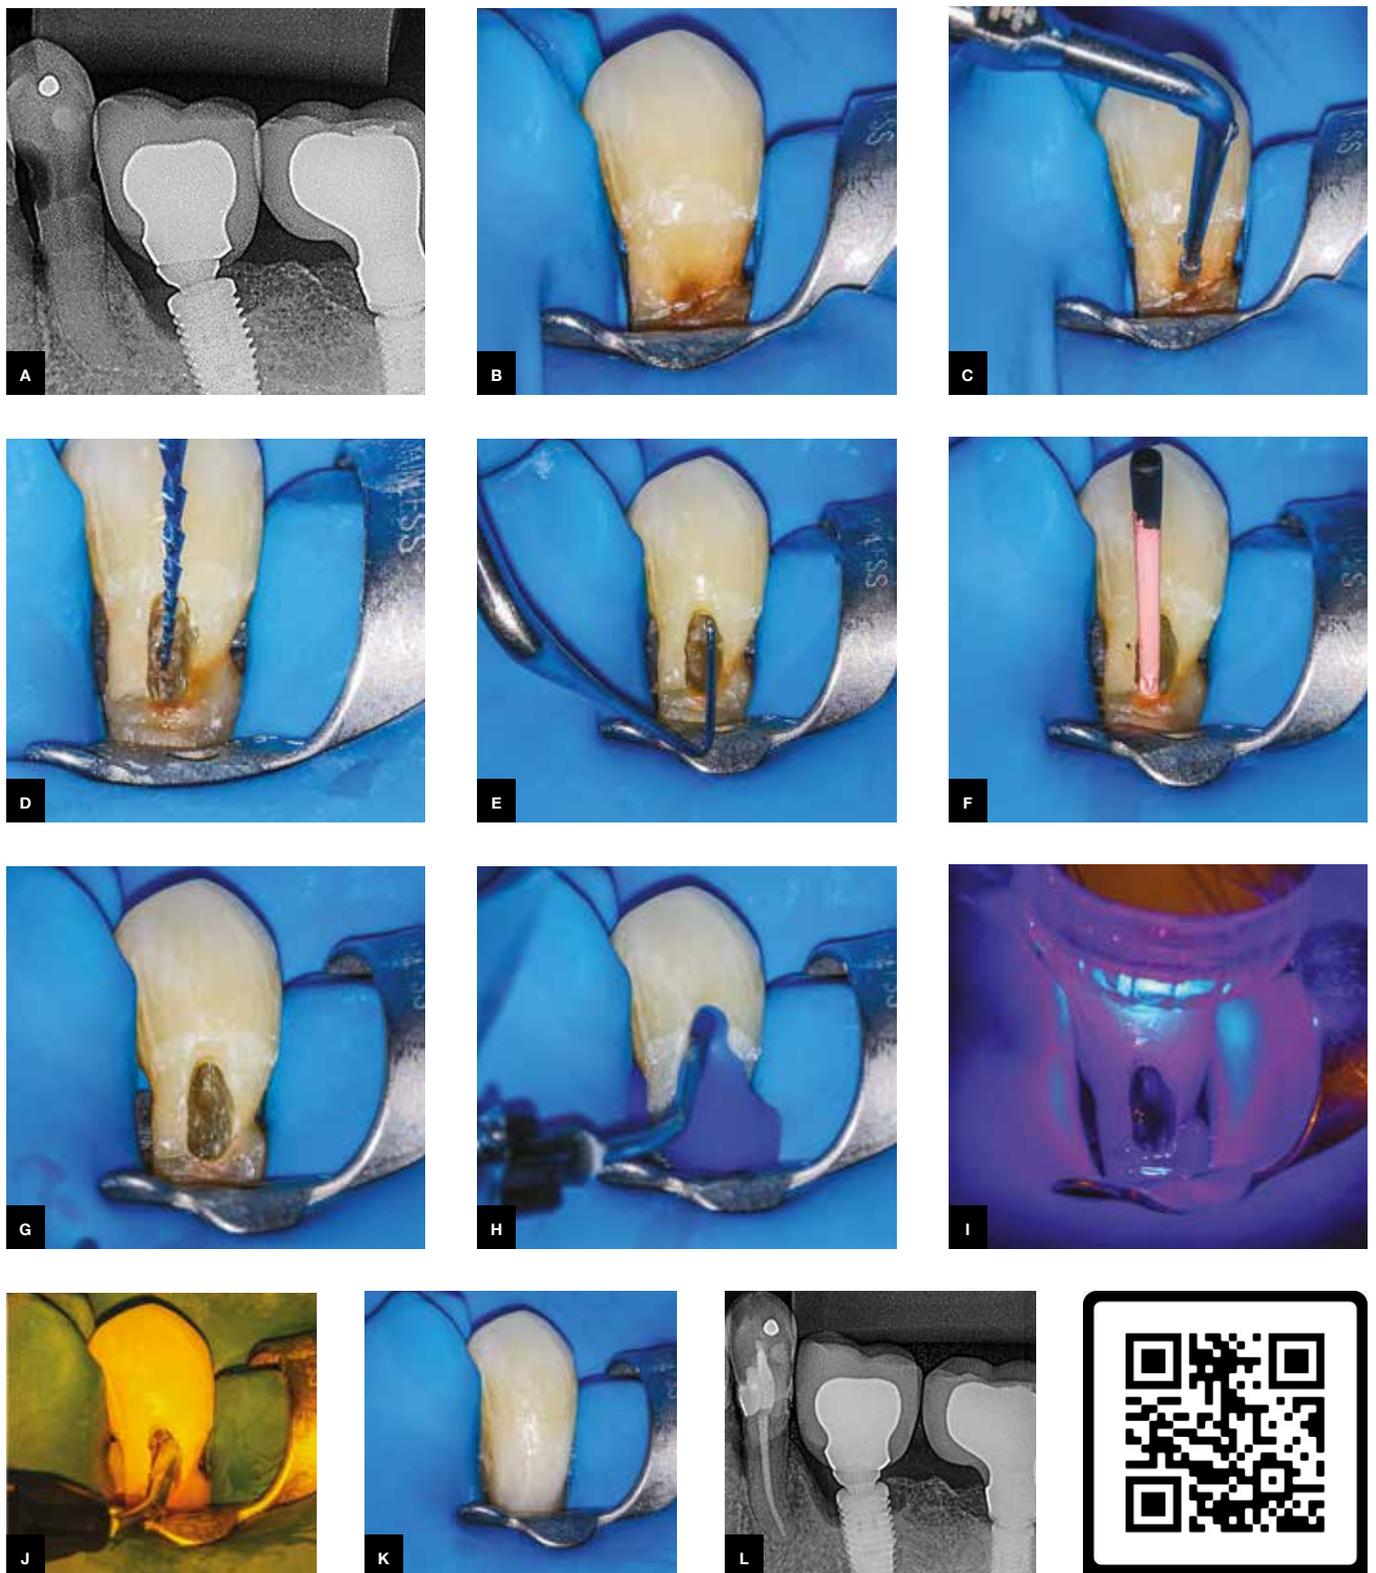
A) Periapical radiograph indicating the presence of caries in tooth #35. B) Visualization of caries in the buccal surface of the tooth. C) Caries removal and endodontic access through the buccal surface, using an E6D ultrasonic insert (Helse Ultrasonic). D) Root canal preparation with Reciproc Blue R25 and R40 instruments. E) Cleaning the roof of pulp chamber with pre-curved ClearSonic ultrasonic insert (Helse Ultrasonic). F) Selection of gutta-percha cones. G) Post-obturation image, showing the absence of filling materials remnants on the dentine walls. H) Acid conditioning with 37% phosphoric acid gel. I) Light curing of the adhesive system (Scotchbond Multipurpose - 3M). J) Restoration with flow resin (Tetric N-Ceram Ivoclar Vivadent). K) Final image of the post-restoration tooth. L) Periapical radiograph of the endodontic treatment. QR Code that refers to a video of the clinical case.
